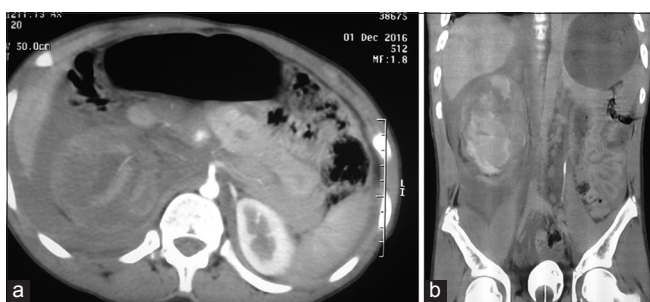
A 17-year-old male patient presented with a renal trauma due to motor car accident and he was hemodynamically unstable. Contrast-enhanced computed tomography revealed Grade 5 right renal trauma. (a) Transverse section. (b) Coronal section. Immediate exploration and total nephrectomy were done
